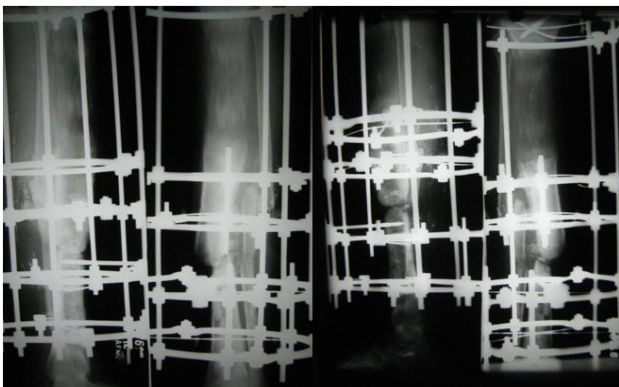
X-ray showing ossification of regenerate in progress following bone transport.
